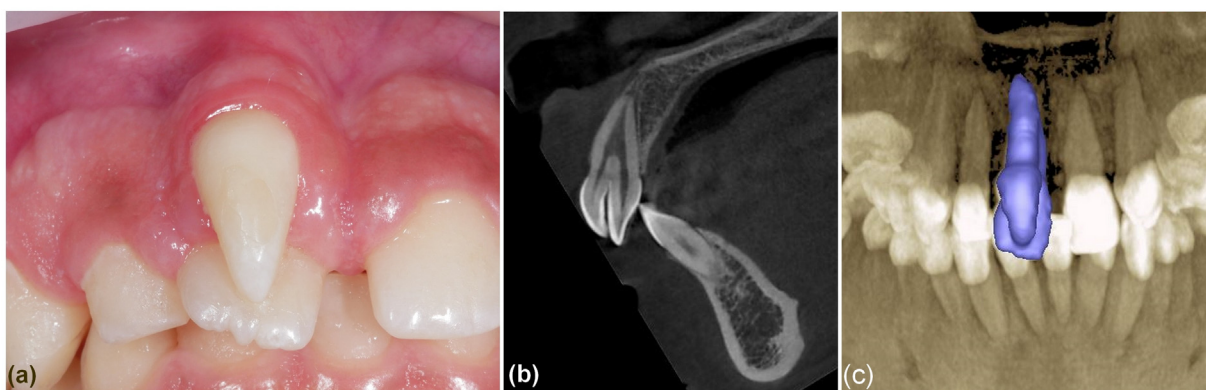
Clinical and radiological examination of tooth 11. (a) Intra oral examination showing the dental malformation with the shape of a fang, above the tooth 11. (b) Cone Beam Computed Tomography (CBCT) showing tooth 11. (c) 3D reconstruction CBCT showing tooth 11.
